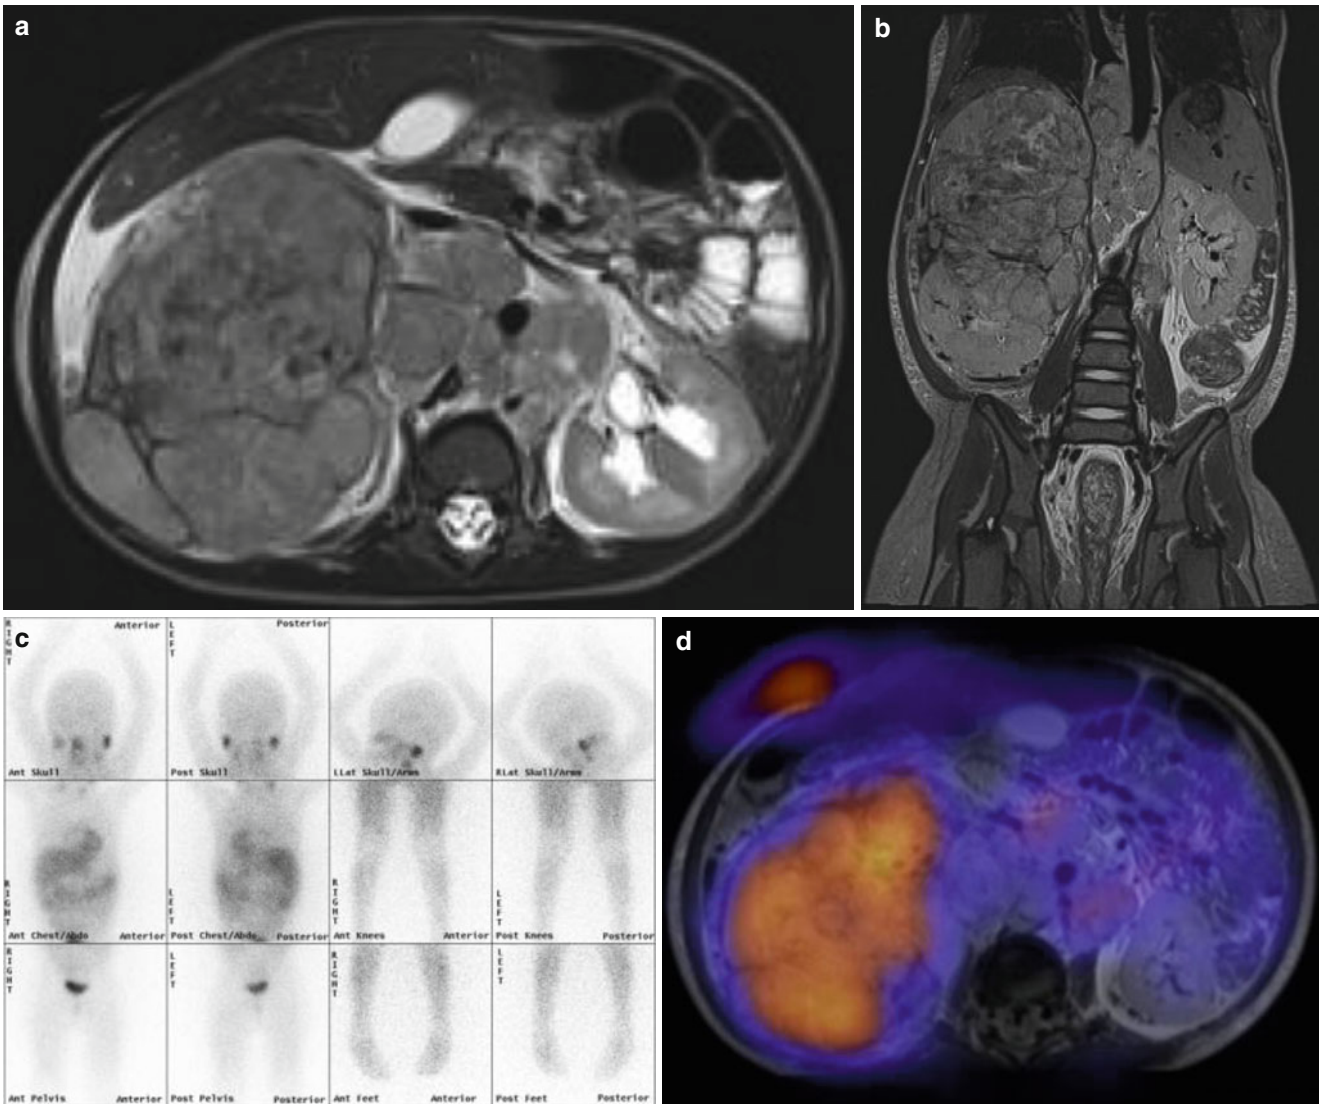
Abdominal neuroblastoma. (a) Axial MRI of the abdomen showing a large retroperitoneal mass. (b) Coronal MRI of the abdomen showing the extent of the retroperitoneal mass. (c) Bone scan showing multiple skeletal metastases. (d) PET scan showing increased metabolic activity in the retroperitoneal mass and skeletal metastases
